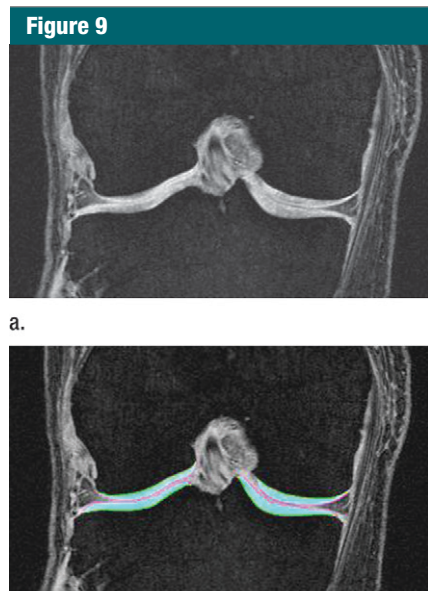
Coronal fast low-angle shot MR images (20/7.6; flip angle, 12°) demonstrate 3D morphometry. (a) Articular cartilage has high intensity signal and high contrast between subchondral bone and cartilage. (b) After manual segmentation, cartilage is outlined and color-coded in turquoise. (Courtesy of Felix Eckstein, MD, Paracelsus Medical University, Salzburg, Austria.)
